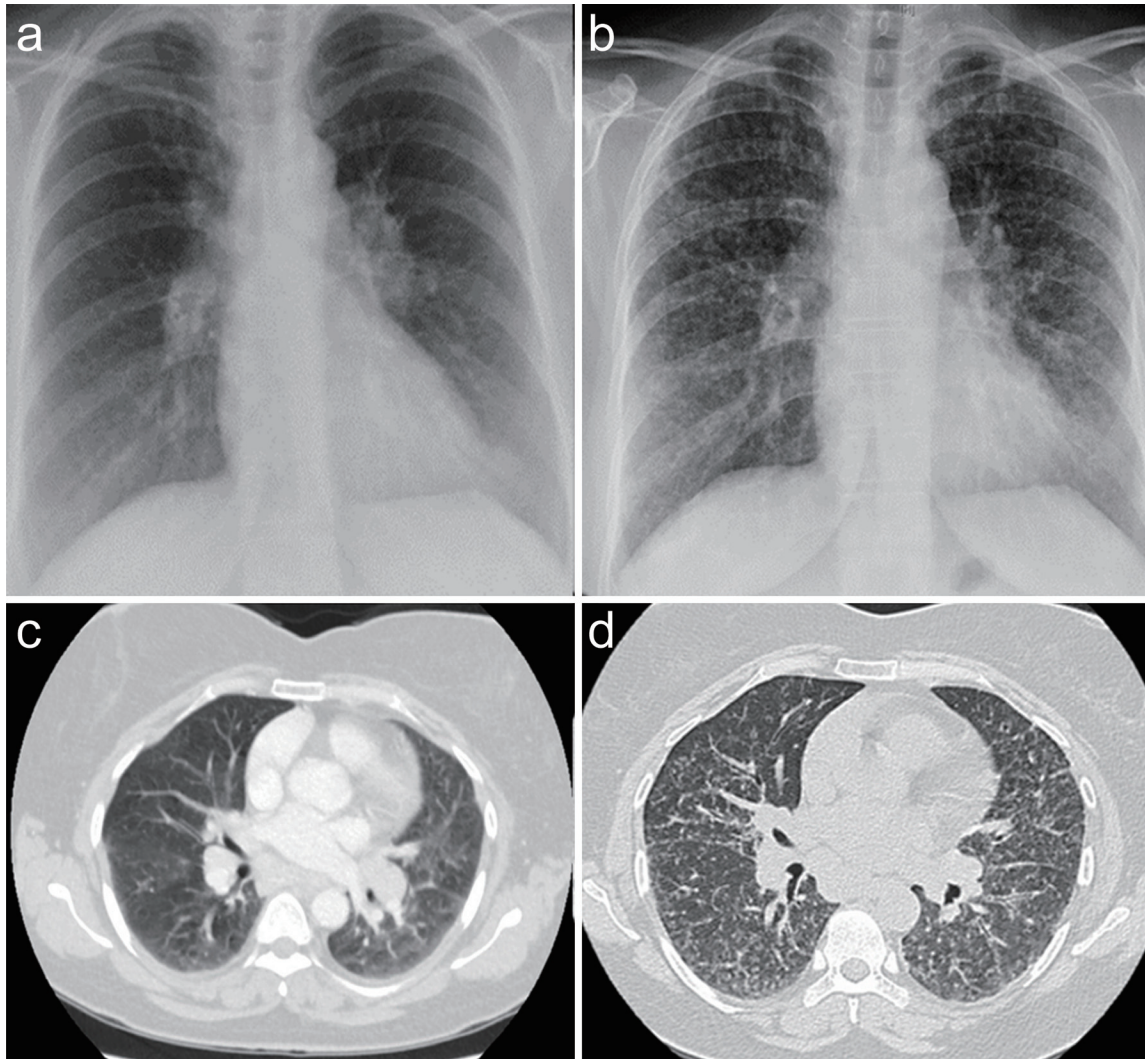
Initial CXR (a) and HRCT (c) chest showed bilateral lymphadenopathy. CXR (b) and HRCT (d) of the chest performed a year later showed a miliary pattern along with bilateral lymphadenopathy. The micronodules were intense, with thickened peribronchovascular interstitium. Contacting micronodules or lines connecting the pleura to the parenchyma can be recognized, which correspond to the perilymphatic pattern, and were occasionally seen in sarcoidosis. In MTB, the micronodules are intense and random in distribution. Perilymphatic changes were not common on HRCT in MTB. CXR, chest X-ray; HRCT, high-resolution computed tomography; MTB, mycobacterium tuberculosis.
